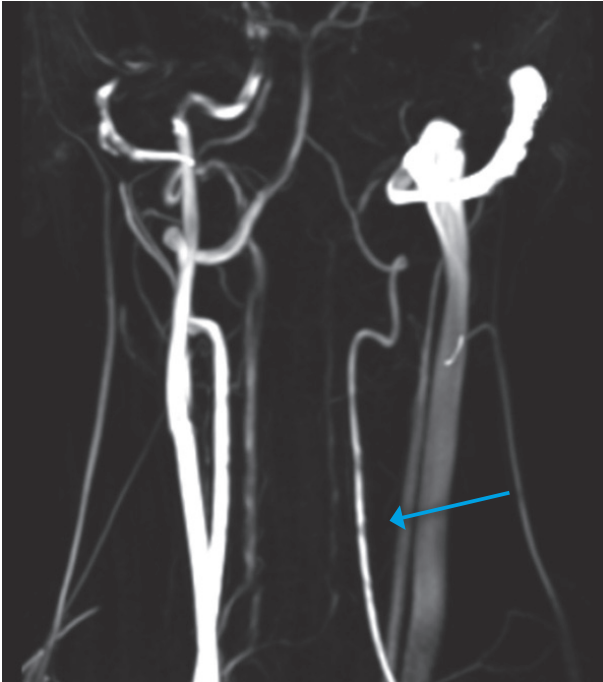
Left common carotid artery dissection with focal stenosis (string sign) on angio-MRI.
